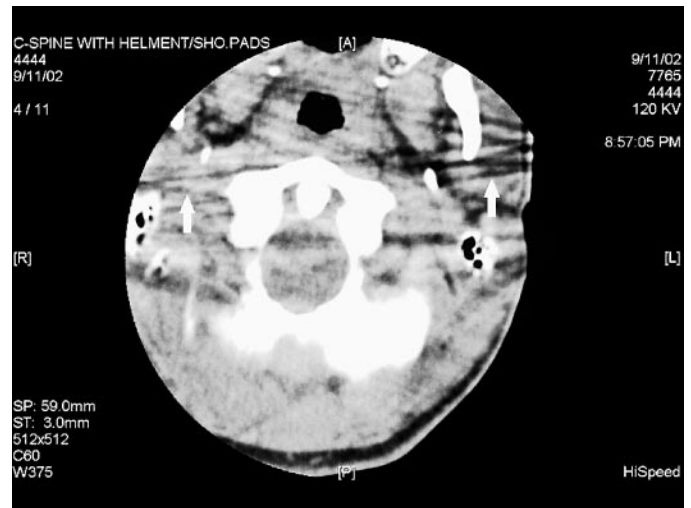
Axial computed tomography (CT) image, soft tissue window, at C1–C2 level. Note the streak artifact (arrows) from the external metal clips. Soft tissue details are preserved, allowing diagnostic film interpretation.
